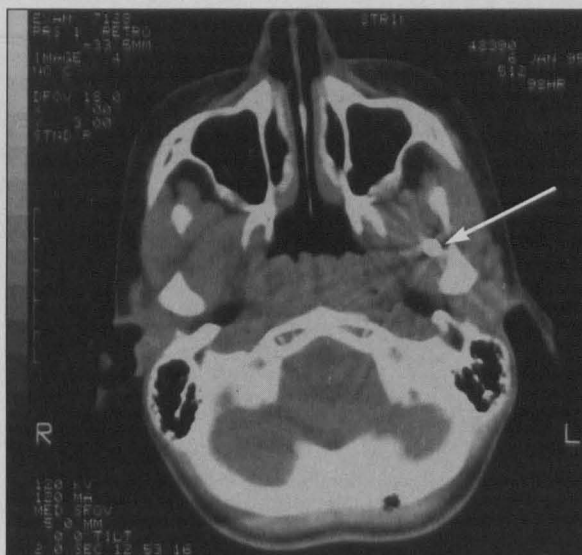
Computed tomographic scan of axial view of skull showing secluded location of BB.
